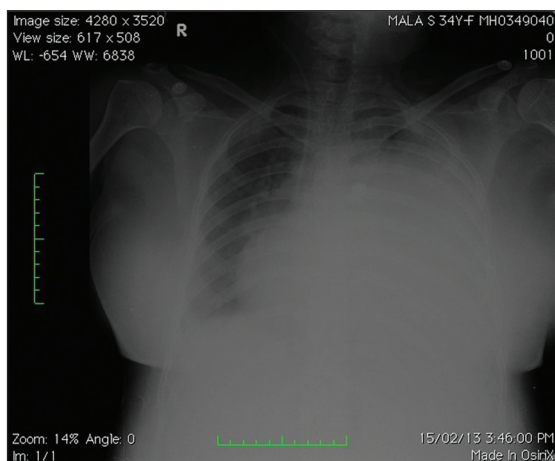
Chest X-ray showing opacity in the left hemithorax
